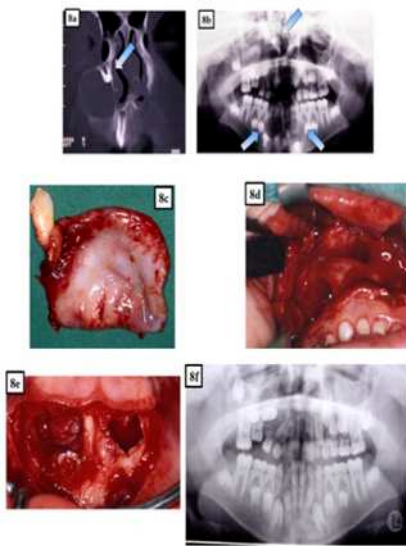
a-f: a, b: Panoramic X-ray and CT show enormous cyst. Cyst development in the maxilla and mandible was the cause of displacement and future retention. c-e: Cystectomy of the maxillary Cyst; Cystotomy of the mandibular cyst. f: OPG a few months after the surgical treatment. There was a spontaneous up righting of the teeth in the lower jaw.
